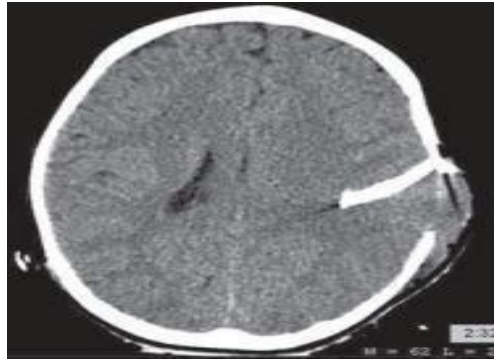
CT Brain Depressed Skull Fracture [29].
